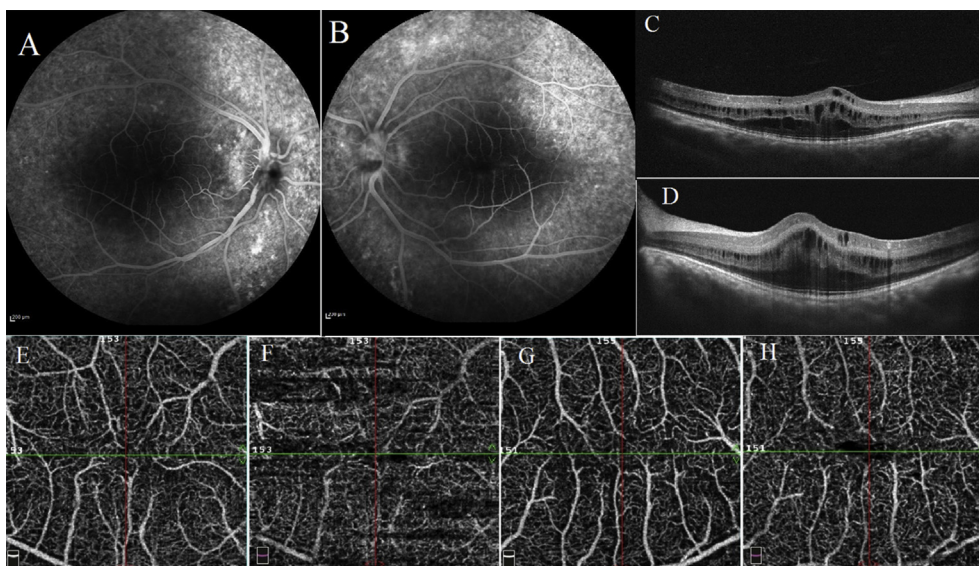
Multimodal imaging of the first case. A and B show the fundus photo. Horizontal elevated papillomacular retinal fold is seen in both eyes. C and D show elevated retinal fold and retinoschisis with intraretinal fluid. No foveal depression is seen, and all layers are preserved all over the retina. E and G superficial plexus of optical coherence tomography angiography (OCTA), and F and H showing deep capillary plexus of OCTA, showing complete foveal vascularization. I shows thickened sclera and shortened eye in B scan ultrasonography. J shows corneal superior steepening in pentacam topography.
